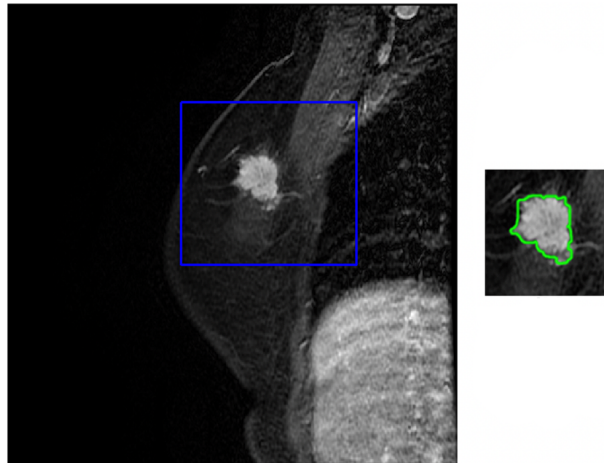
Example of a contrast-enhanced breast lesion on MRI. Adapted from [29].
